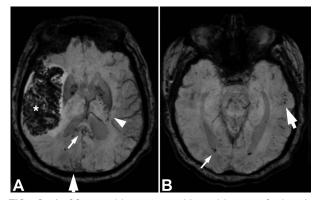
A 69-year-old woman with a history of chronic obstructive pulmonary disease hospitalized for COVID-19 pneumonia complicated by ARDS and acute kidney injury requiring hemodialysis presented with left-sided weakness. A. Susceptibility-weighted images of a brain MRI shows hemorrhagic conversion of a right middle cerebral artery stroke stroke (asterisk) and microhemorrhage in the corpus callosum (*solid thin arrow*), the posterior limb of the internal capsule (*arrowhead*), and cortex and subcortical white matter (*solid thick arrow*). B. The same patient also demonstrated interventricular hemorrhage layering in the occipital horns of the lateral ventricles (*solid thin arrow*) and additional foci of cortical/subcortical microhemorrhage (*solid thick arrow*).
